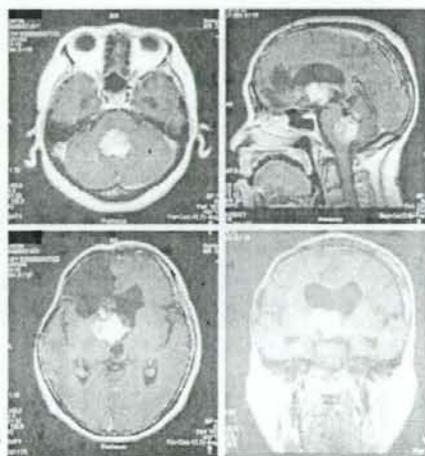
MRI at the time of second recurrence shows enlargement of the fourth ventricular and lateral ventricular tumors as well as hydrocephalus
